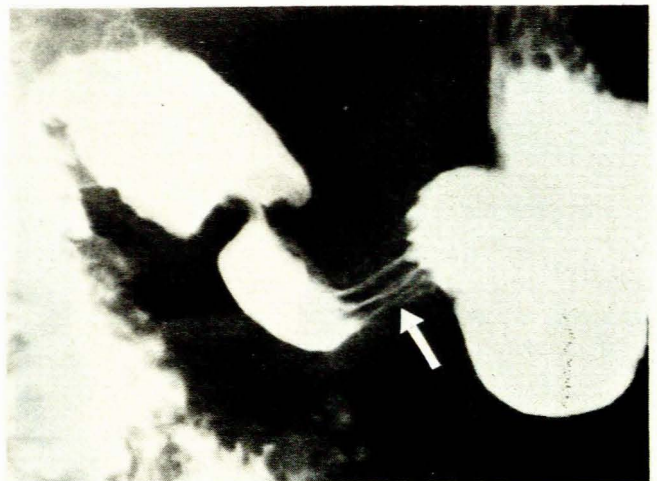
Radiograph showing normal tube-like contraction of pyloric sphincteric cylinder. Arrow denotes point at which peristaltic wave becomes stationary.
